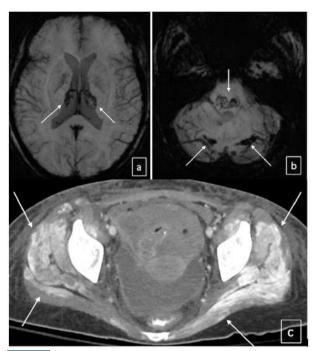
A young woman found wandering the desert for multiple days presented with altered mental status and clinically found to have heat stroke. Axial SWI MIP images (a, b) demonstrate bilateral hemorrhagic thalamic infarcts (arrows), with additional hemorrhagic rhombencephalitis (arrows), a presumed sequelae of heat stroke. Axial CT image in soft tissue window (c) demonstrates a striated and hyperattenuating appearance of the bilateral gluteal musculature (arrows), which was postulated to represent heterotopic calcification secondary to rhabdomyolysis
